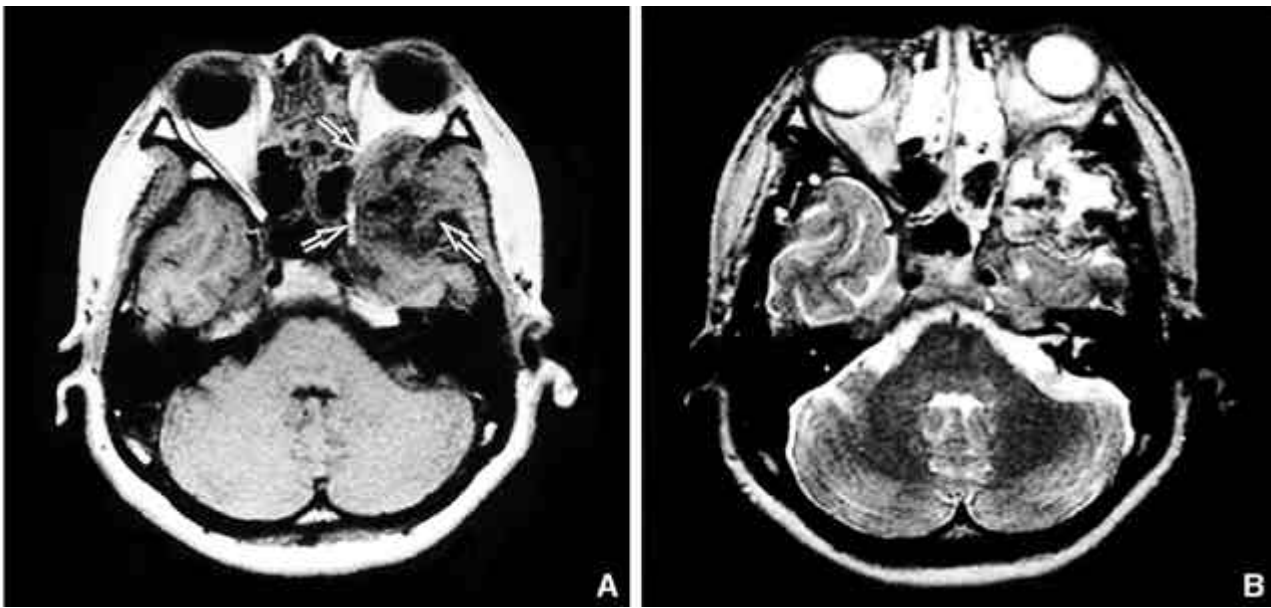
Axial T1-weighted MR image (A) shows a heterogeneously hypointense lesion on the left greater wing of sphenoid bone (arrow), which is hyperintense with multiple signal voids on T2-weighted image (B).
